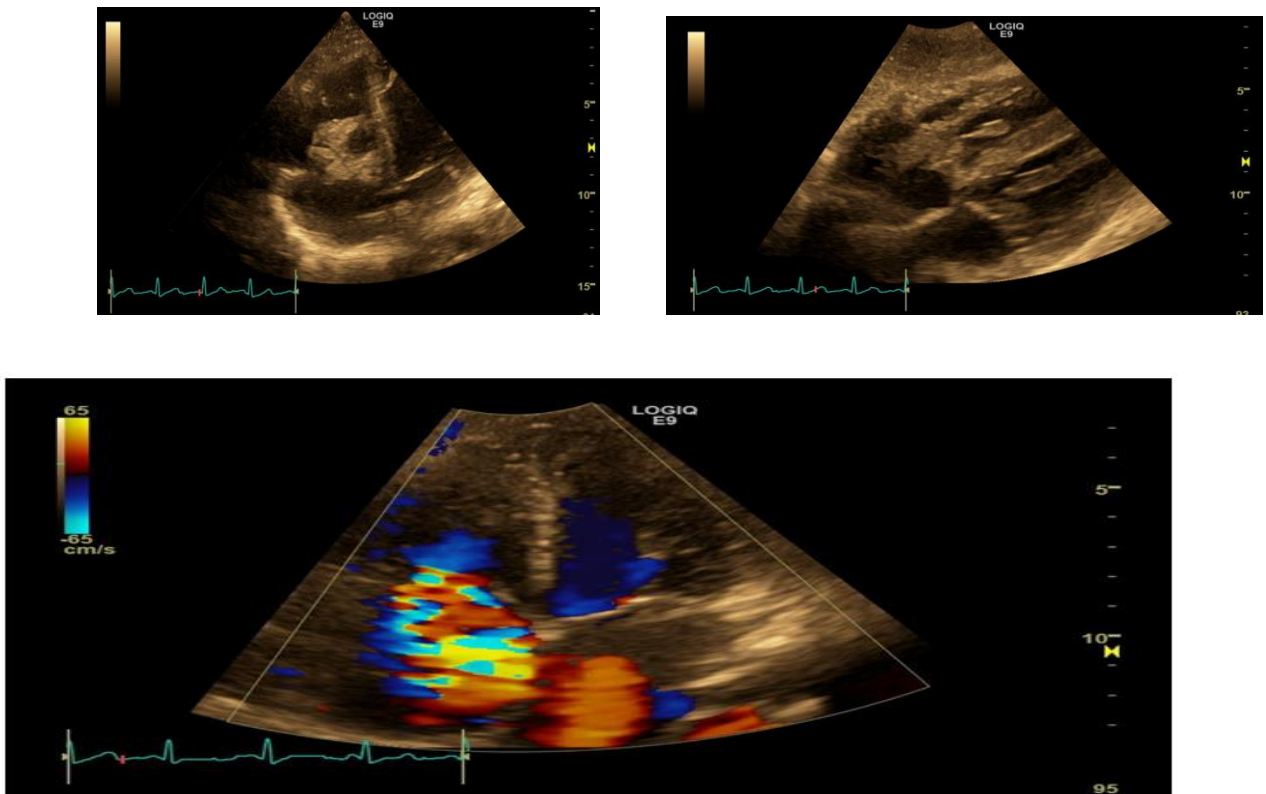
Transthoracic echocardiography showing: Large tricuspid valve vegetation (yellow arrow) sized 3.62 x 1.6 cm in the A) 4 chamber view, and also seen in the B) substernal view. C) Color doppler shows severe tricuspid valve regurgitations.
